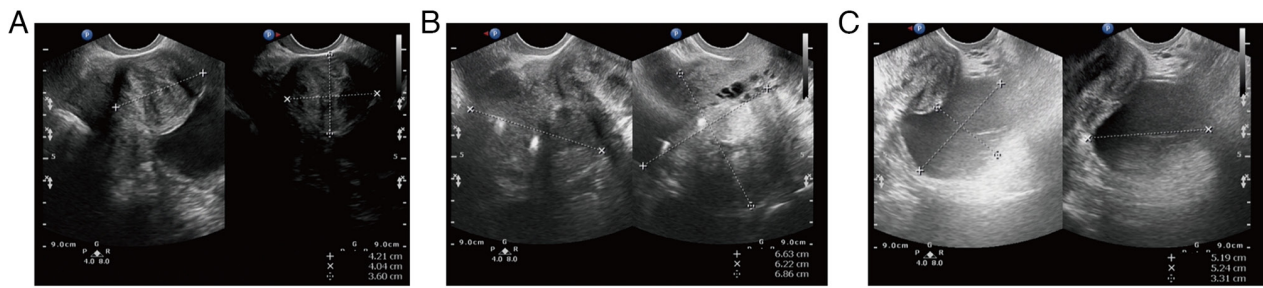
Ultrasound images. (A) Multiple inhomogeneous hypoechoic echoes without obvious blood flow signals between the uterine muscle. (B) The uterus was measured ~69x66x62 mm. (C) A 52x52x33 mm anechoic area is visible in the left ovary without an unmistakable blood flow signal.
